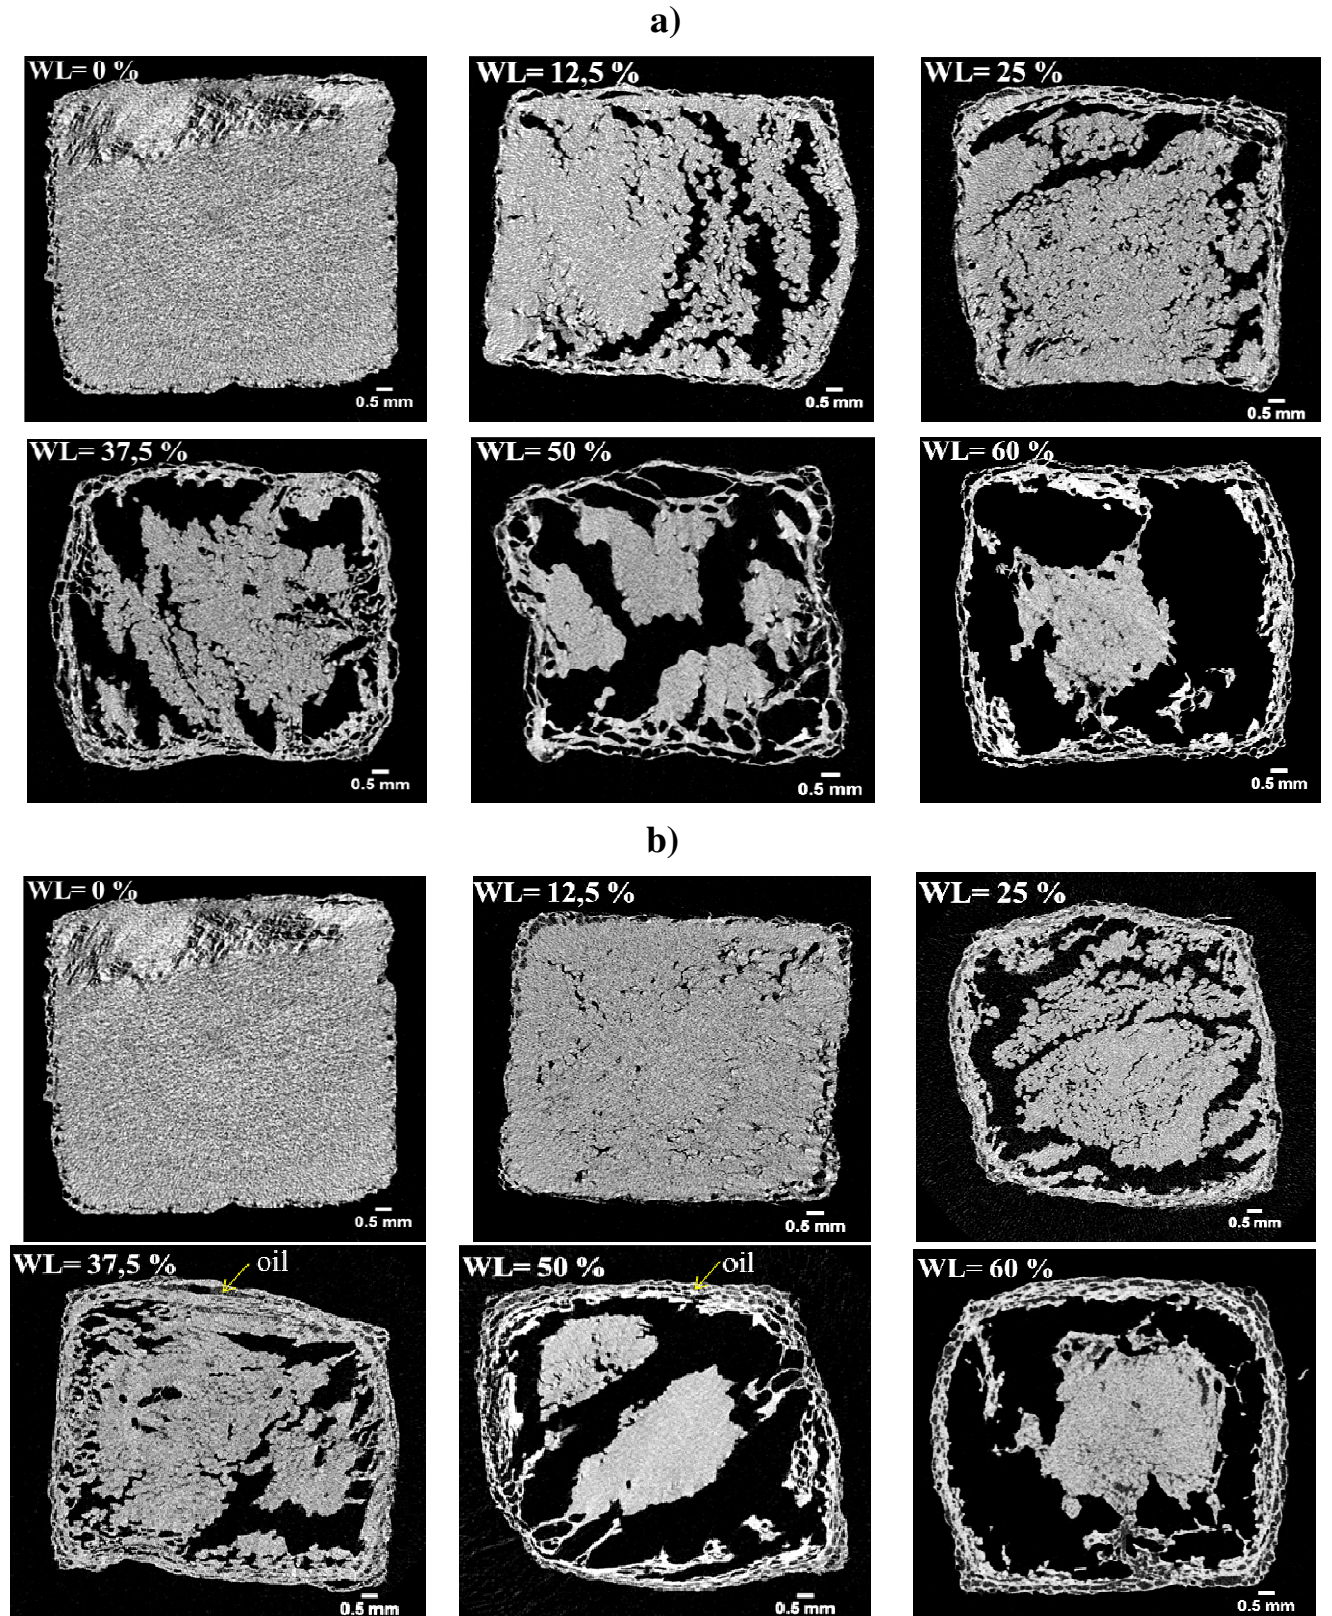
Cross-sectional slices (2D images) obtained from X-ray micro-computed tomography of a) hot-air fries and b) deep-fat fries as a function of water loss (WL) expressed in kg of water per kg of initial mass.
